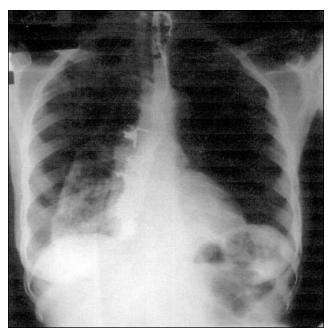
Preoperative chest radiograph of patient 3, with contrast.
